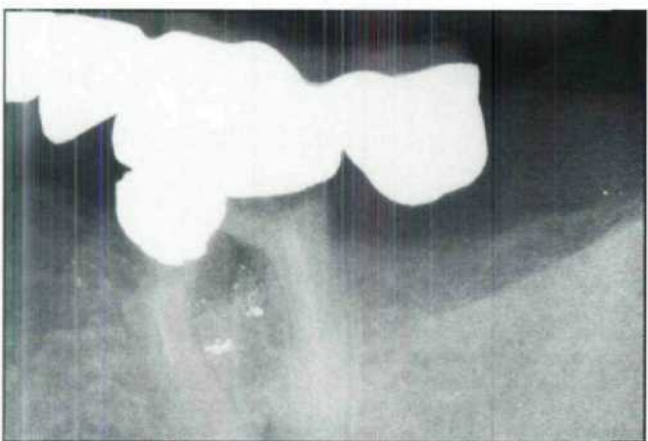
Case 3. The preoperative radiograph demonstrated decay and mesial root and furcation involvement.
